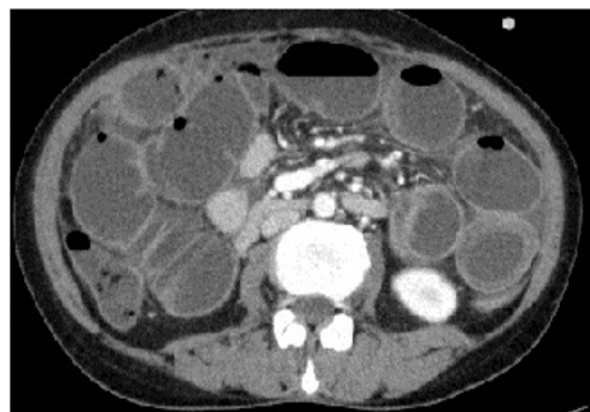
CT scan Image showing dilated bowel loops as a part of intestinal obstruction
